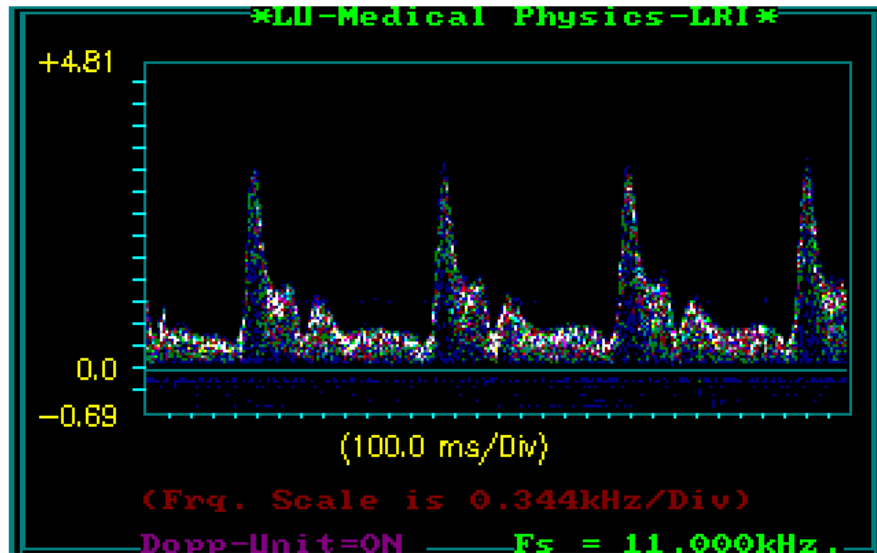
An example of the Doppler sonogram display.
